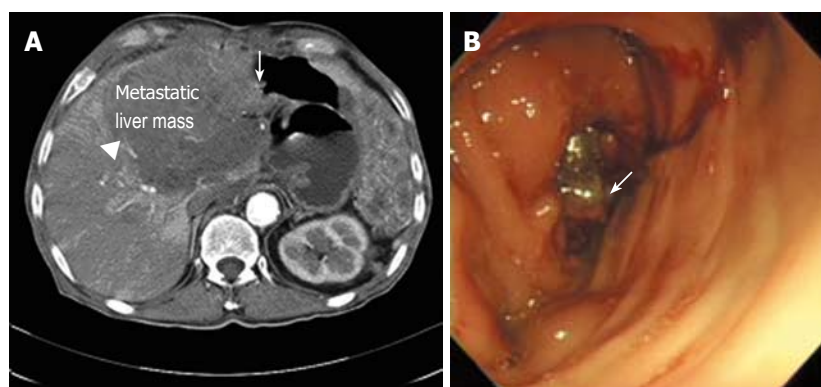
Diagnostic evaluations of recurrent gastrointestinal stromal tumors before starting sunitinib. A: In computed tomography, arrowhead and arrow show metastatic liver mass and colon invasion, respectively. B: In the colonoscopic finding, arrow shows a protruding mass invading from the external lumen.
